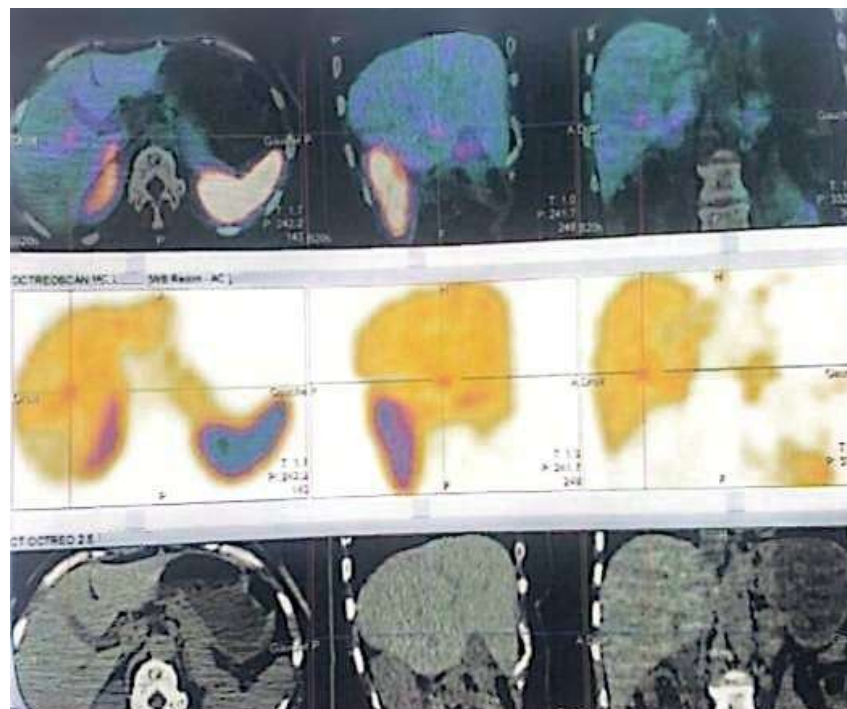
SPECT/CT image of a 99mTc-Tektrotyd® scintigraphy showing hepatic lesions corresponding to secondary metastases (representative case).
